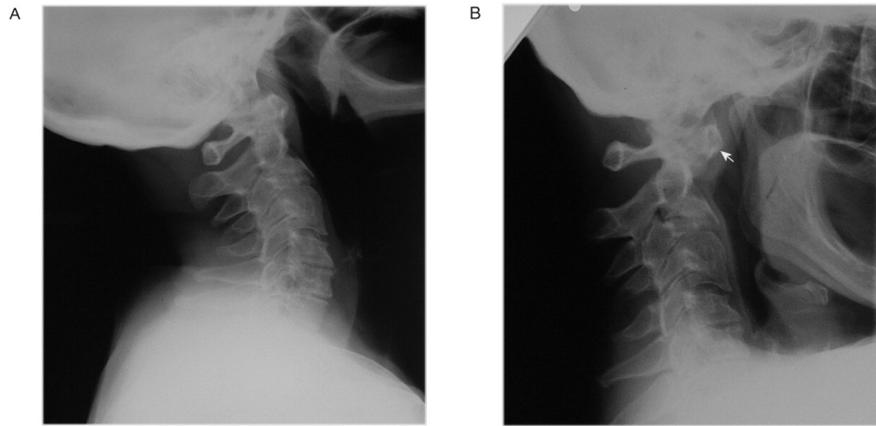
Cervical spine X-rays in a patient with severe rheumatoid arthritis on long term steroids showing anterior atlanto-axial subluxation (with permission from Oxford University Press). A- extension. B- flexion: Demonstrates severe anterior atlanto-axial subluxation. Note the position of dens axis (arrow). There is a 13 mm dislocation between the dens and the main body of the axis. C3 shows degenerative changes.
